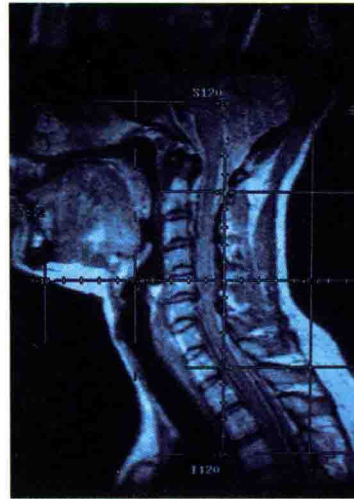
MRI of the Neck
